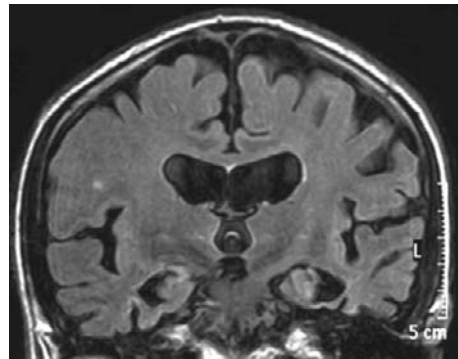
Semantic dementia. Shown is a coronal FLAIR image from a 72-year-old man with progressive anomia. Although the patient's spontaneous language was almost normal, he could not name by confrontation objects as common as a table. Note the marked atrophy in the anterior portion of the temporal lobes, more pronounced on the left.
